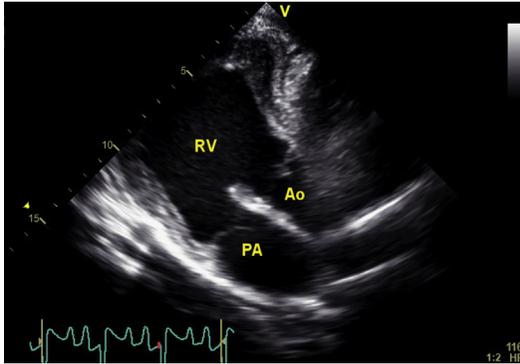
2D B-mode recording, right parasternal long-axis, RVOT view. This calf has a DORV; with both the Ao and PA visualized next to each other and connected with the RV.
